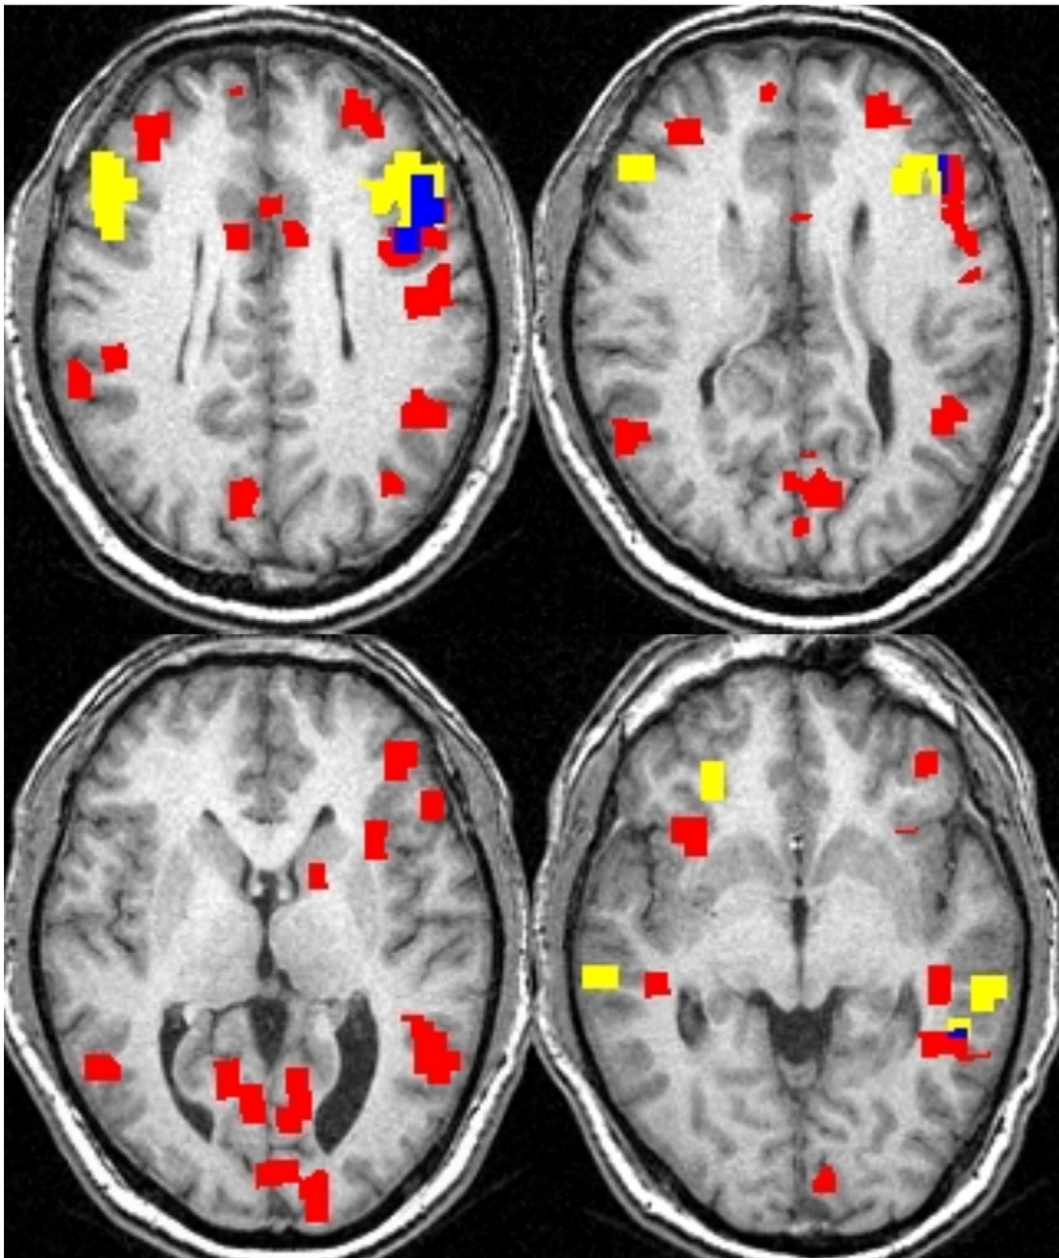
Functional MRI axial images showing pre- and postoperative activation from the audio sentence task. Areas of preoperative activation are depicted in yellow; areas of postoperative activation in red and overlap in blue.
